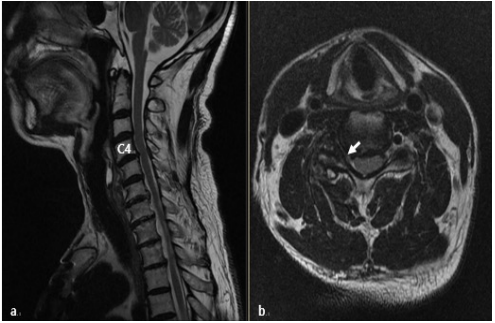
Cervical spine MRI
